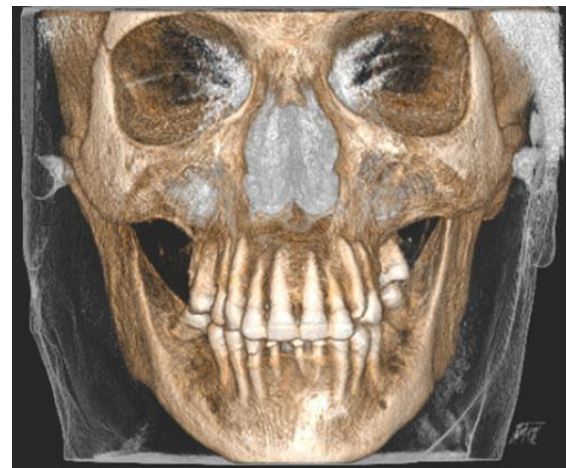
CT scan demonstrated expanded facial space of buccal and temporal area compared to left side of her face.
